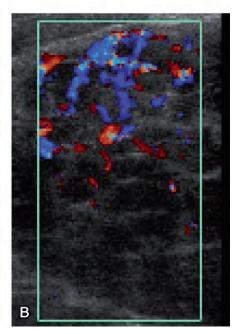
Ultrasound of plasmacytoma in the right lobe. A, Transverse. B, Color Doppler, transverse.
